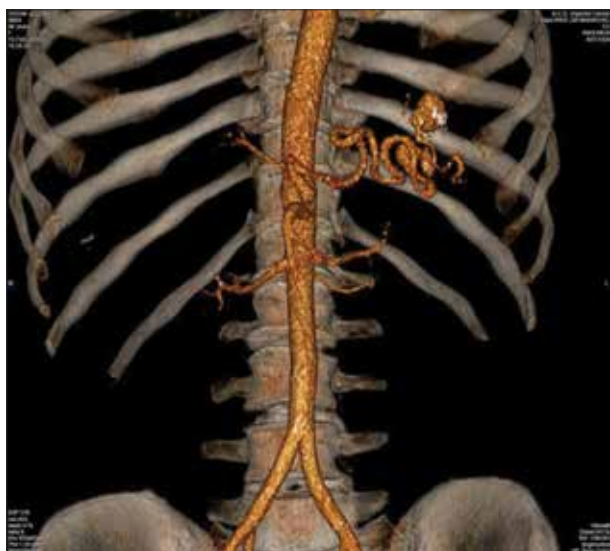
Multidetector computed tomography angiography showed splenic artery aneurysm in the splenic hilum
